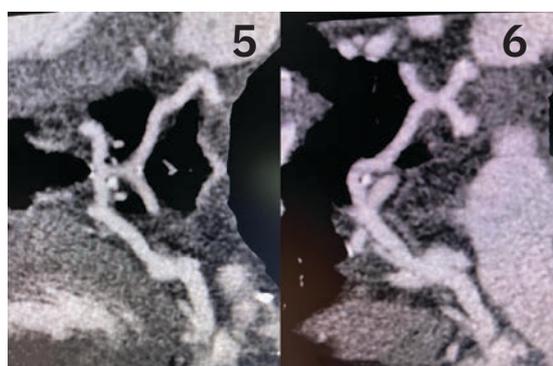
Post operative axial view of coronary computed tomography angiography post left coronary artery ligation, showing the left coronary artery no longer connected to the pulmonary artery.
